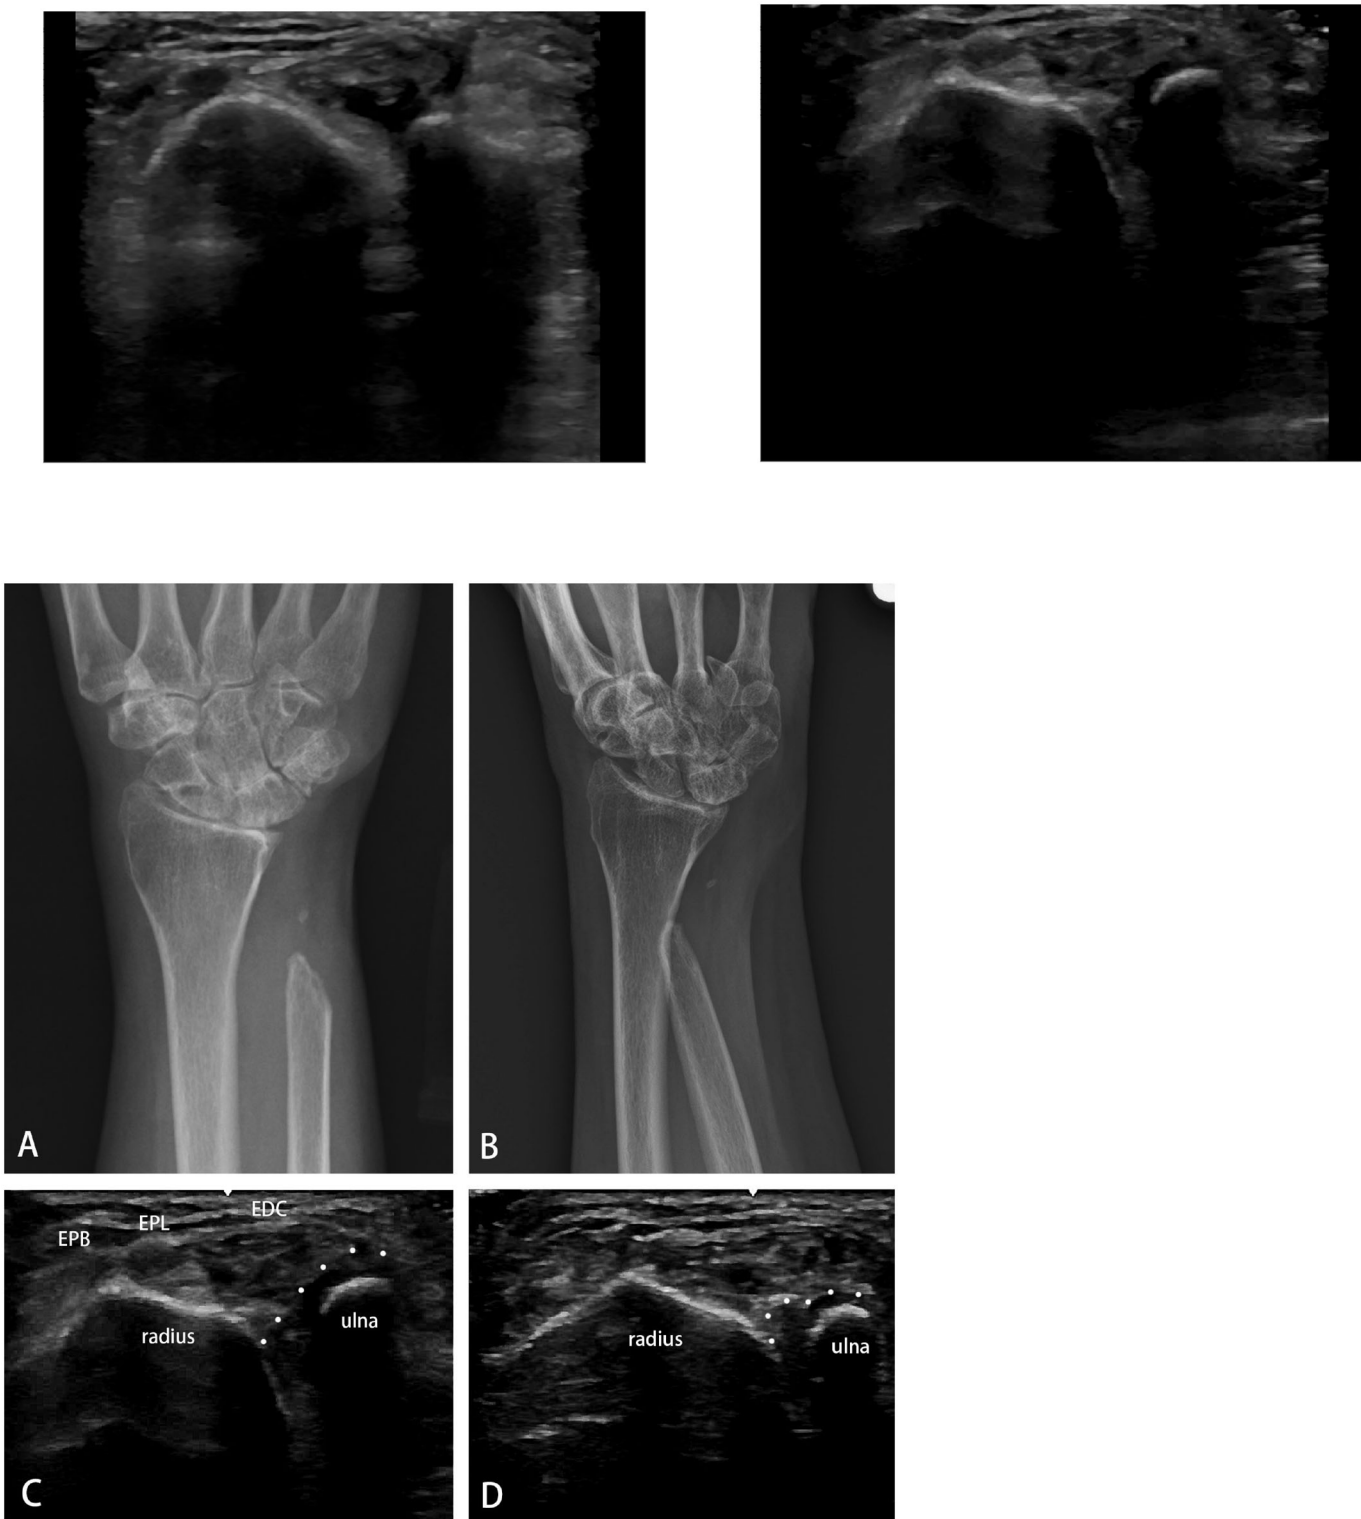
AP (A) and Scheker’s (B) view of a 62-year-old female 4 years after the Darrach procedure. Dynamic ulnar impingement would have been diagnosed with the radiographs. However, ultrasonography transitioning from baseline (C) to holding a 1-kg weight (D) revealed the PQ (dotted) interposed between the radius and ulna, forming a gap measured 1 mm.
